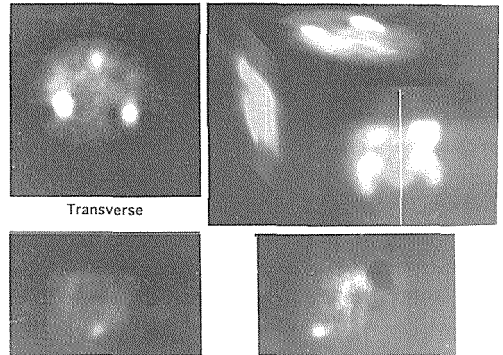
¹¹¹In-octreotide SPECT of abdomen. Small intestine carcinoid.
